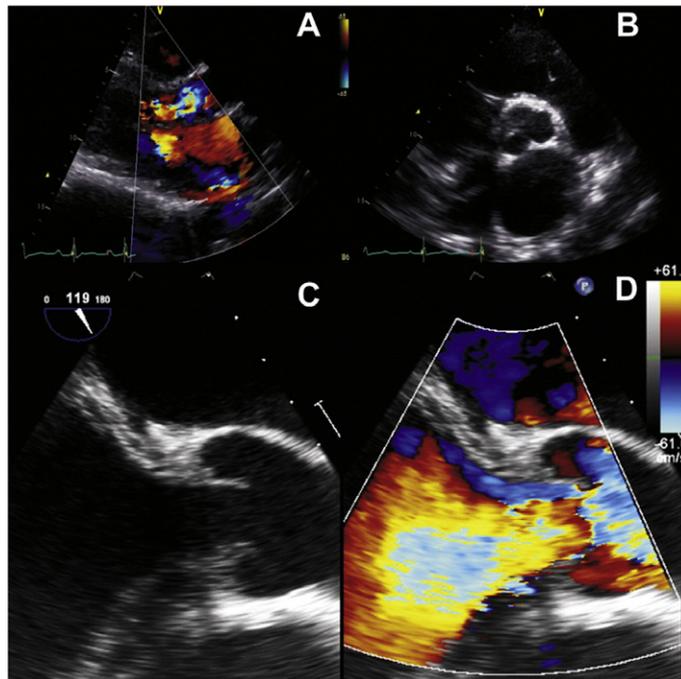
Severe, torrential aortic regurgitation demonstrated on color Doppler analysis (A: parasternal long-axis view on transthoracic echocardiography; D: mid-esophageal long-axis view on transesophageal echocardiography). Aortic valve leaflets were abnormally thickened (C: mid-esophageal long-axis view on transesophageal echocardiography), however, the morphology of the aortic valve was rather difficult to appreciate on echocardiography (B: parasternal short-axis view on transthoracic echocardiography).
